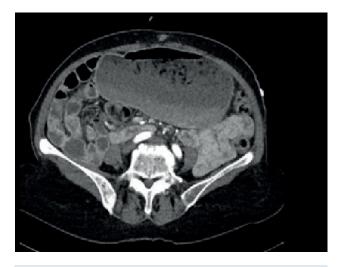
Transverse plane of the stomach on abdominal CT
